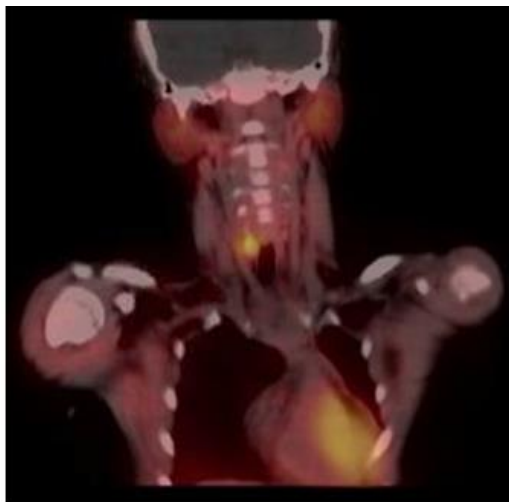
Spect CT demonstrating parathyroid adenoma in the right lower parathyroid gland.
